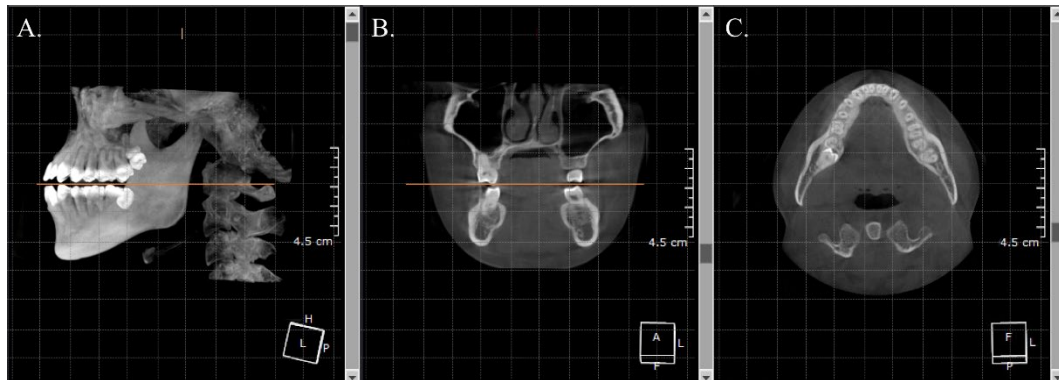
CBCT reorientation using image analysis software
